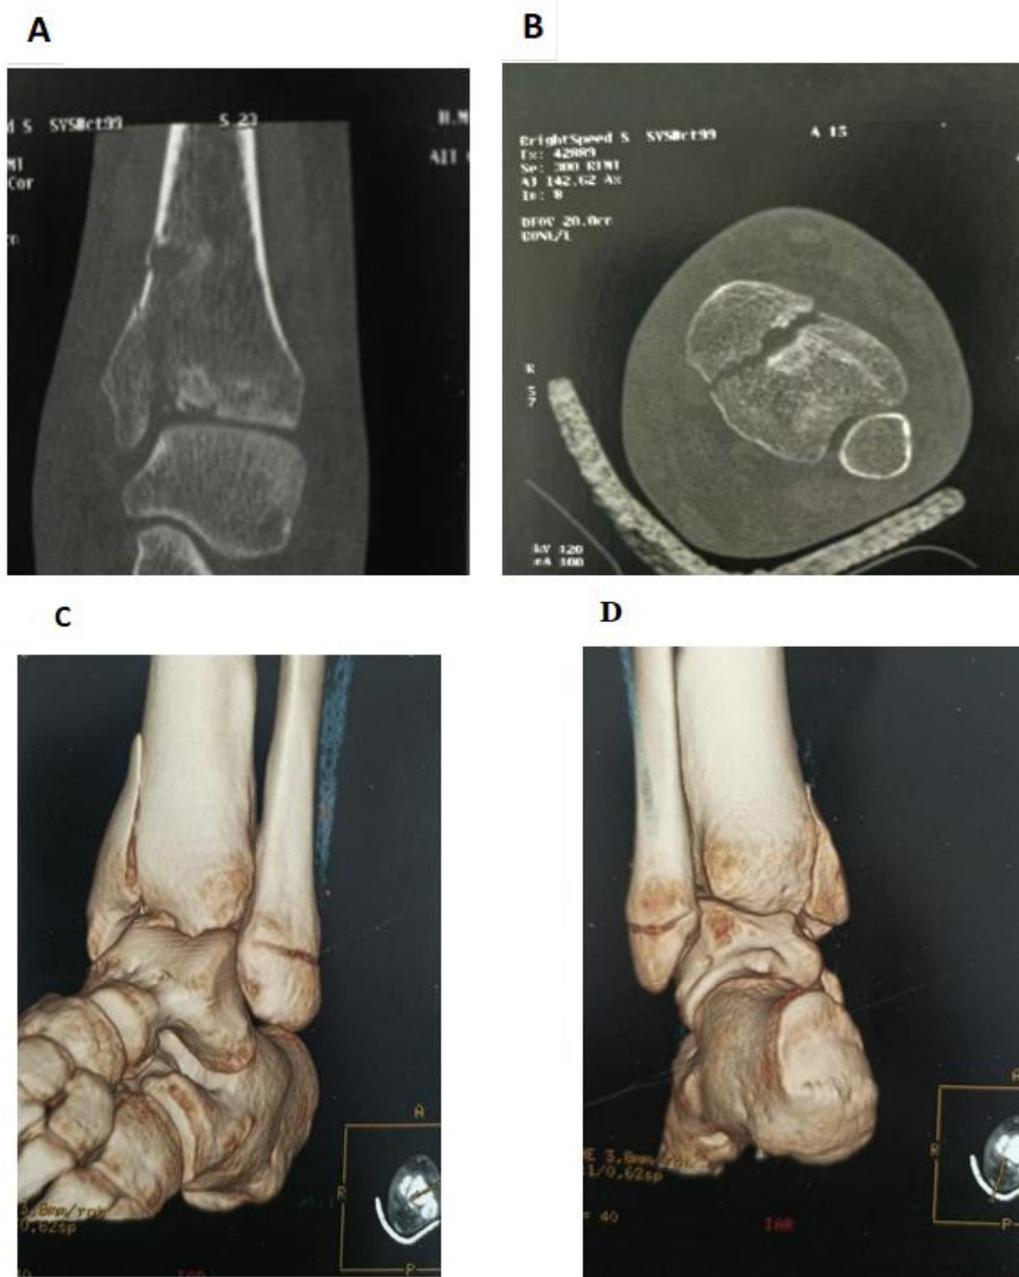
(A B, C, D): Computed Tomography scan of the left ankle showing pilon and lateral malleolus fractures with more details
